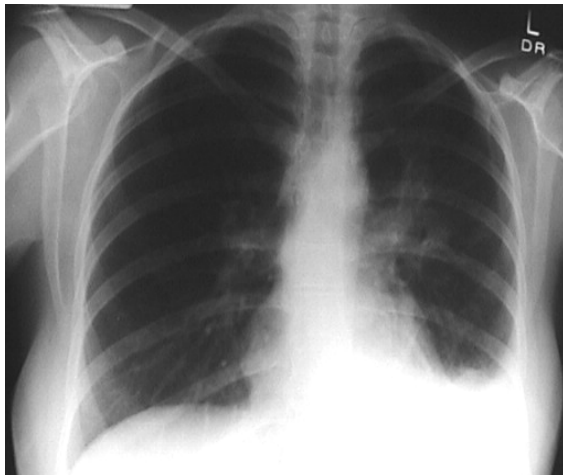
Plain Chest X-ray
